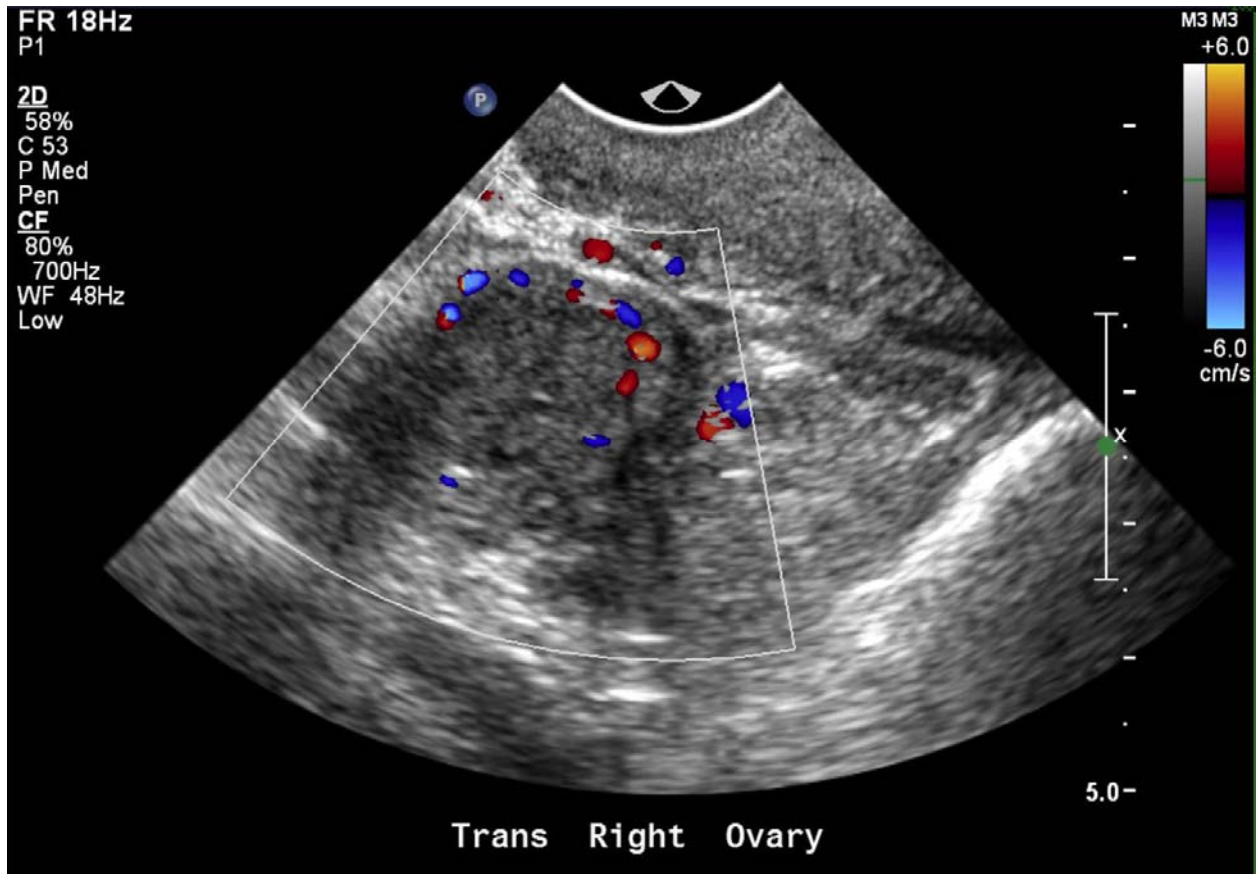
Endovaginal transverse grayscale ultrasound image with color Doppler of the right ovary shows increased intratumoral blood flow within the right ovarian mass. The right ovary was not tender to transducer palpation.
